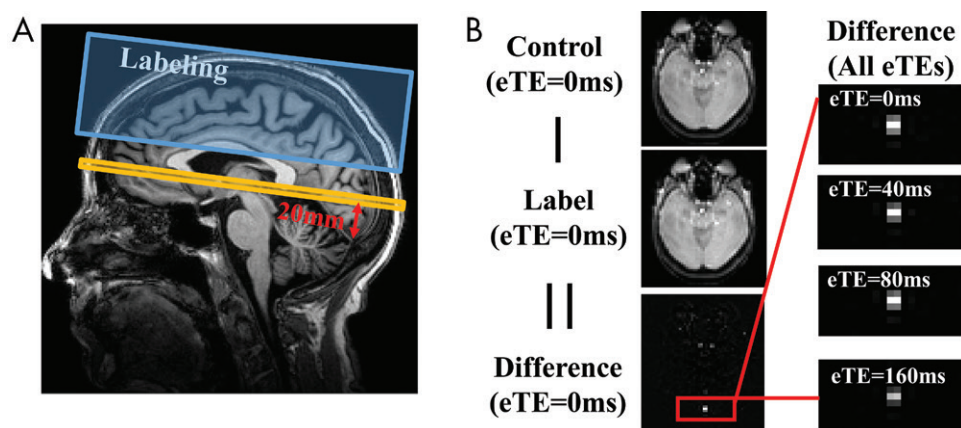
Images show typical results of T2-relaxation-under-spin-tagging (or TRUST) MRI. A, Position of image plane for TRUST MRI. Yellow bar indicates imaging slice. Blue box indicates labeling slab. B, Representative images of TRUST MRI for quantification of cerebral venous oxygenation. Paired subtraction between control and label images results in a different image, in which superior sagittal sinus (red box) is prominent. Fitting of signal as function of effective echo time (eTE) results in estimation of venous blood T2. Blood T2 can then be converted to oxygenation level by using calibration plot established in literature.
